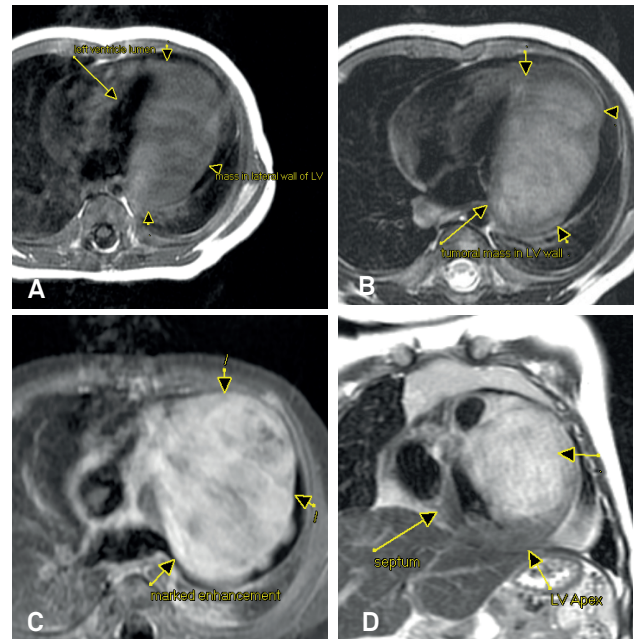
Pre contrast MRI images of the chest were obtained using TSET1W sequence in axial planes (a) Cardiomegaly due to large tumoral mass lesion (60x34 mm) involving lateral wall of left ventricle. It is isointense to muscle on T1W images; Pre contrast MRI images of the chest were obtained using TSE/T2W sequence with fat suppression in axial and coronal planes (b), it is markedly hyperintense on T2W images. There are a few septa or bant like hyperintensities with in lesion; Post contrast images were done using TSE / T1W sequence in axial planes (c, d) On post contrast study it show avid enhancement. Left ventricle volume is decreased. Mild pericardial effusion is also noted. (International Health Center "IHC" Pristina City, Kosovo)
